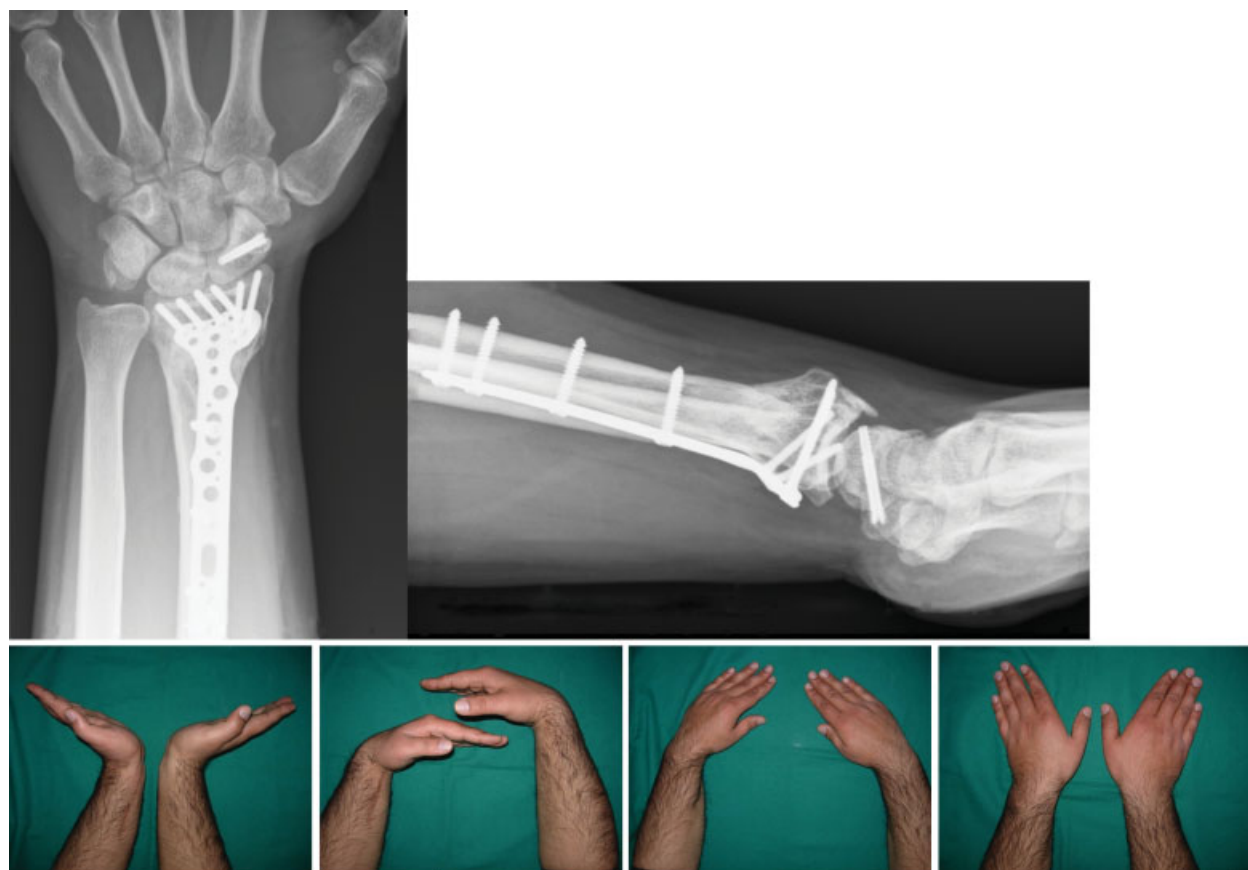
Clinical and radiographic results at 20 months.
